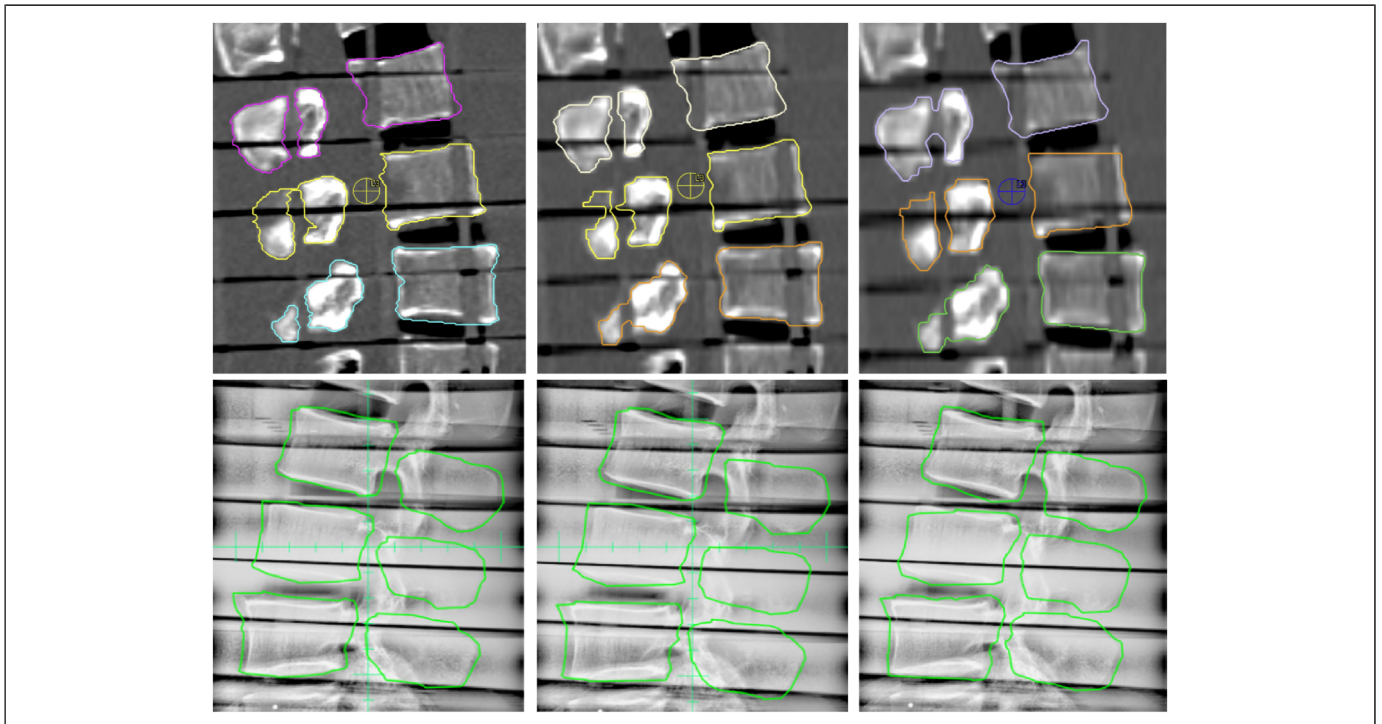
IGRT structures on the planning CT images (upper row) and the triggered kV images (lower row). From left to right, CT slice thicknesses are 1 mm, 2 mm, and 3 mm. Slice thickness and level of outline details are inversely related.
